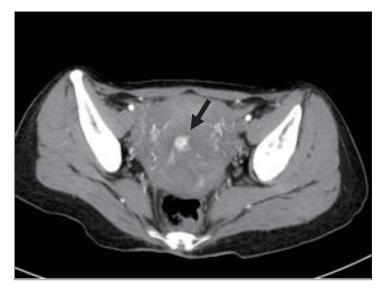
Computed tomography (CT) images. Dynamic enhanced CT during the arterial phase showed a hypervascular lesion (arrow) in the uterine cavity corresponding to a retained product of conception.
